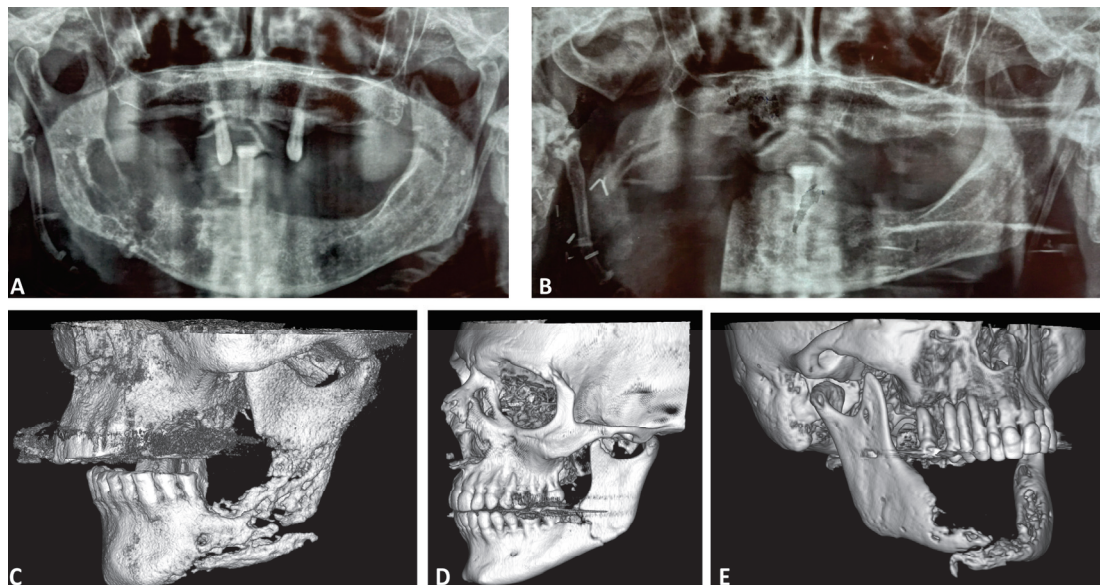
Imaging modalities of selected patients. (A) OPG of a female patient (78 years old) diagnosed with a mandibular pathological fracture of the right mandibular body due to MRONJ. (B) OPG of the same patient postoperatively, after right segmental mandibulectomy. (C) Three-dimensional anasynthesis of a CT scan of a male patient (83 years old) with a mandibular pathological fracture of the left angle due to osteoradionecrosis. (D) Three-dimensional anasynthesis of a CT scan of a male patient (50 years old) with a mandibular pathological fracture of the left angle after surgical extraction of a low-level-impacted third molar. (E) Three-dimensional anasynthesis of a CT scan of a female patient (64 years old) with an extended mandibular pathological fracture of the mandible due to malignancy.
